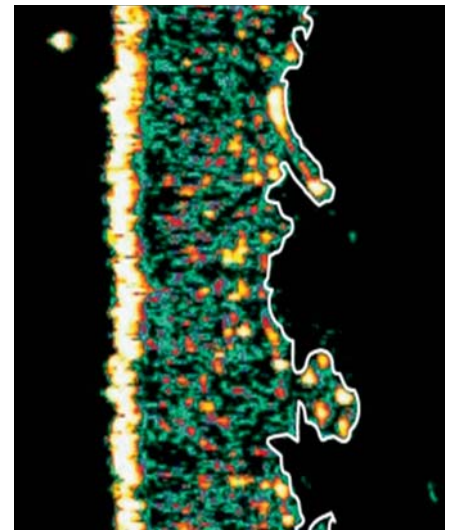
Postflight skin physiological measurements: ultrasound images, R +62 days.
